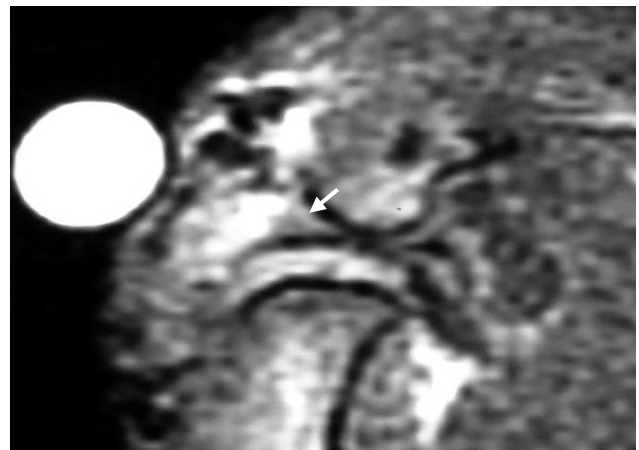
Partial discectomy with collagen template implantation: no regeneration. Follow-up T1-weighted MR image (TR=300 ms, TE=20 ms) of left knee 8 weeks after partial meniscectomy (anterior horn) shows a heterogeneous high signal intensity of the anterior horn of the meniscus (arrow). Note that signal intensity difference of the failure regeneration of the anterior meniscus as compared to the normal posterior horn of the meniscus.
